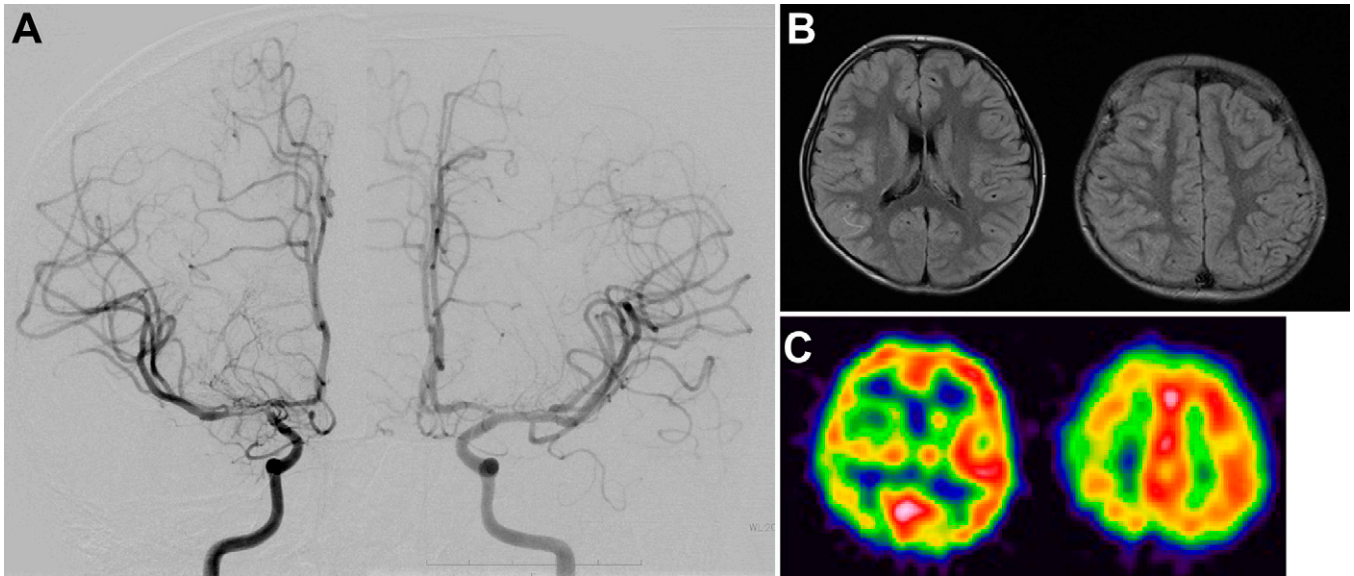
Images taken during the onset of symptoms in a 9-year-old boy who initially presented with transient left upper limb weakness. A: Cerebral angiography showed mild stenosis of the right ICA terminal and development of Moyamoya vessels. B: No significant ischemic lesions were observed on FLAIR using MRI. C: SPECT showed a marked decrease in the CBF in the right MCA territory.
